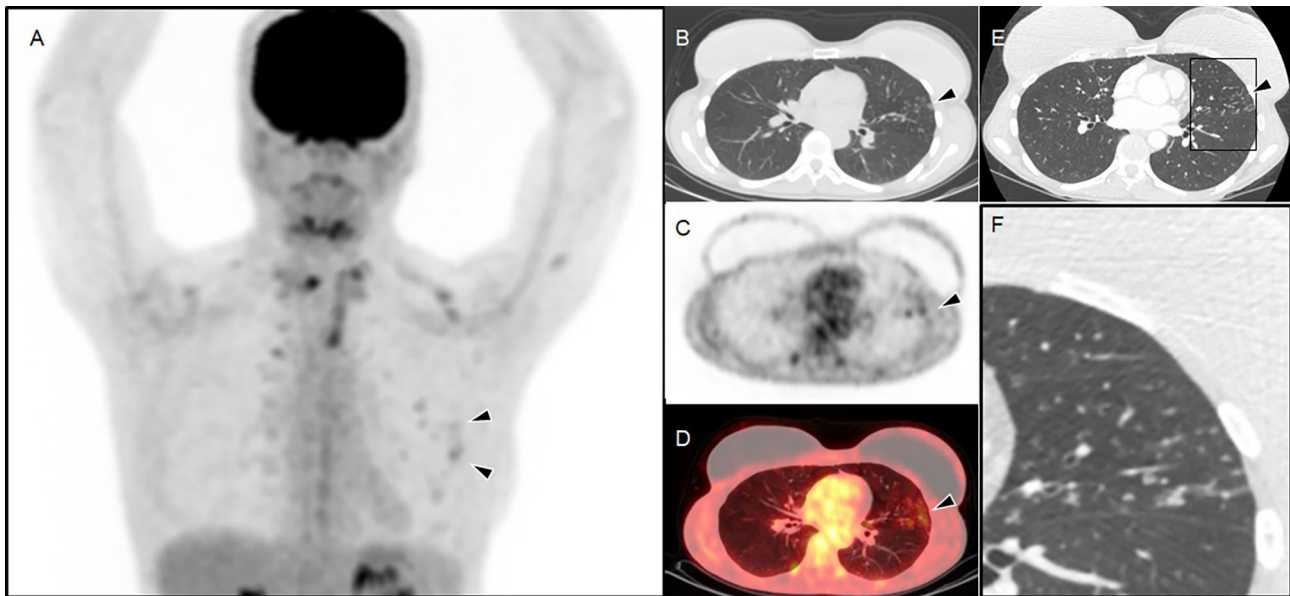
Imaging to characterize extent of structural disease. PET/CT images including a maximum intensity projection (MIP), b CT, c PET, d transaxial fused PET/CT. CT scan performed following
